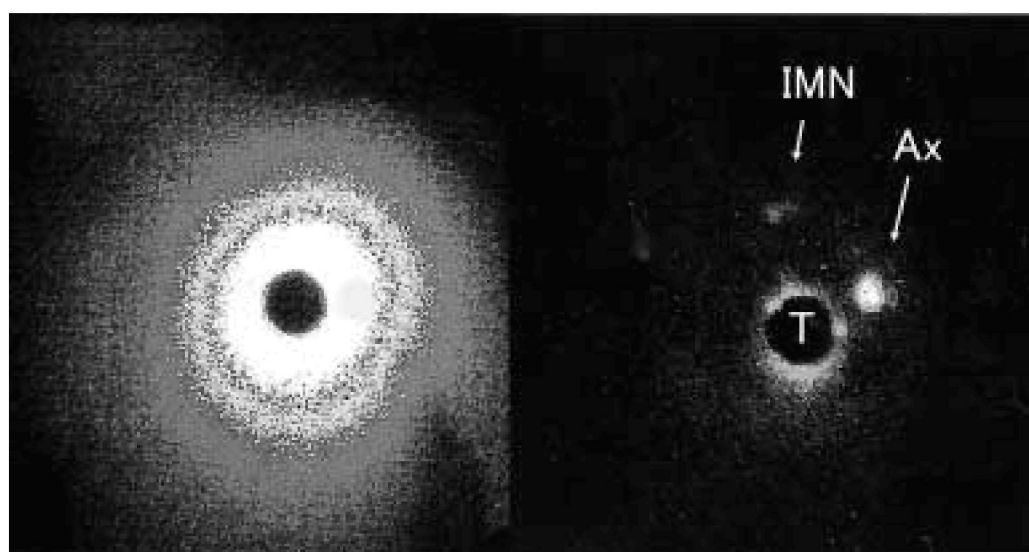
Two sentinel lymph nodes detected in the internal mammary region and axilla by lymphoscintigraphy at the time of primary operation (Case 2).
